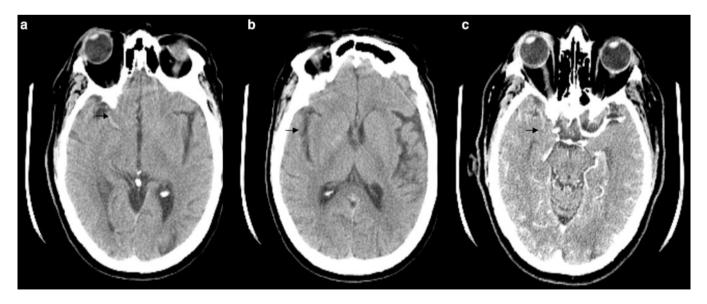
Early CT signs in acute stroke. CT performed 1 h after onset of left hemiparesis. (a) Hyperdense MCA (*left, arrowhead*) and (b) loss of insular ribbon (*middle, arrowhead*) are shown on non-contrast CT. (c) MCA occlusion detected on CT-angiogram (*right, arrowhead*).
